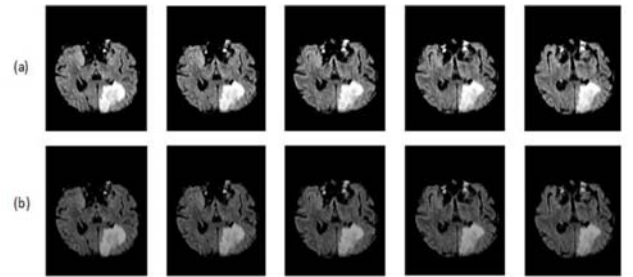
Image de-noising by implementing Curvelet transform using MRI images of the brain from BRATS 2013 dataset. The upper row(a) represents original images while below row(b) explains enhanced images after Curvelet transform.
